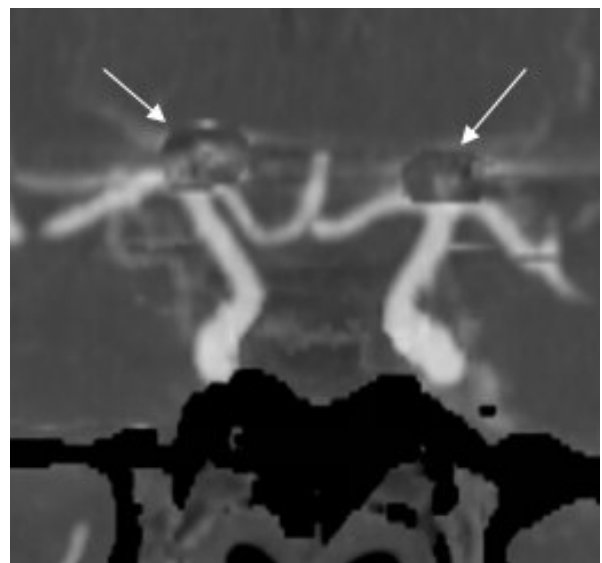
Maximum intensity projection image of CTA of the brain showing the artefacts associated with the coil embolization of the mirror aneurysm (white arrows)
